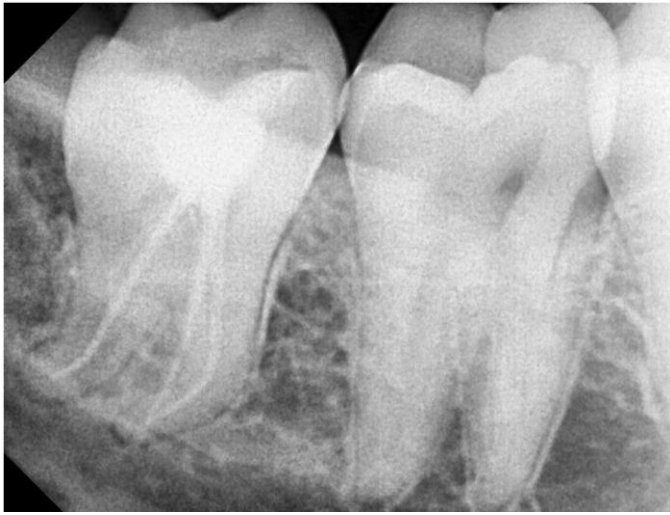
D: Post Obturation Radiograph
